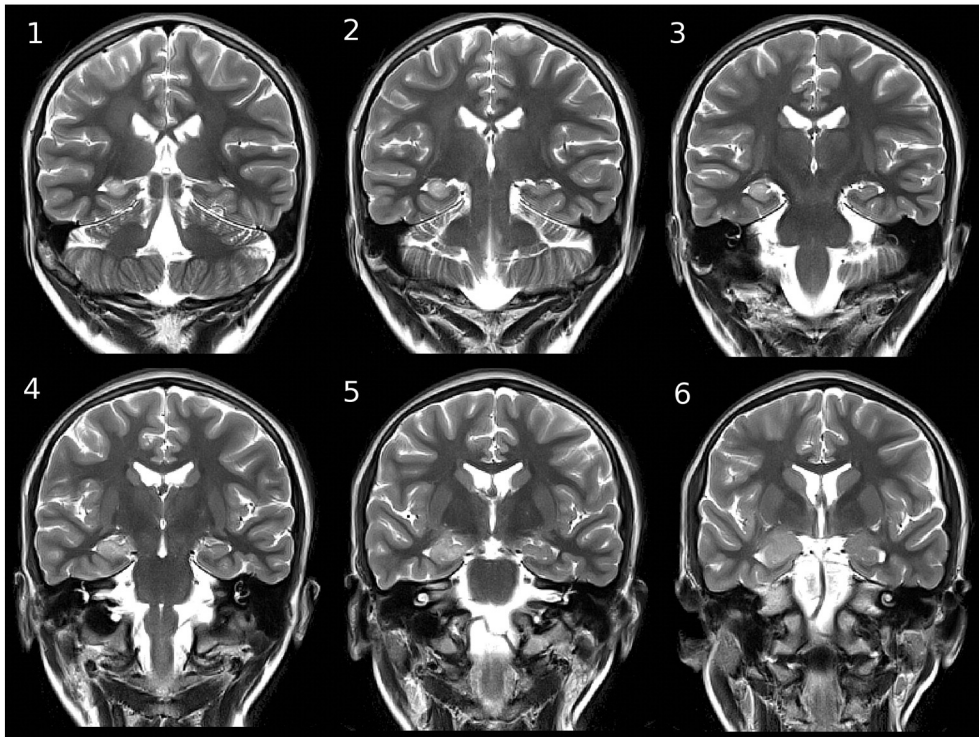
Clinical *in vivo* T2-weighted image. Higher intensity is observed in right hippocampus (left-side on image) and amygdala. The clinical diagnosis indicated secondary hippocampal edema.
